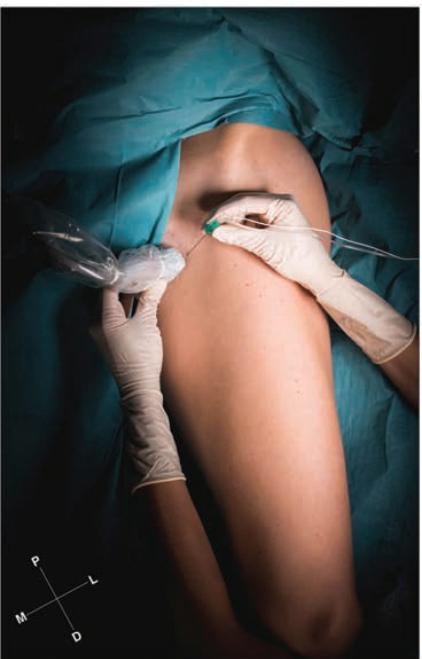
Distal approach to block the obturator nerve; reverse ultrasound anatomy with needle insertion in-plane.
